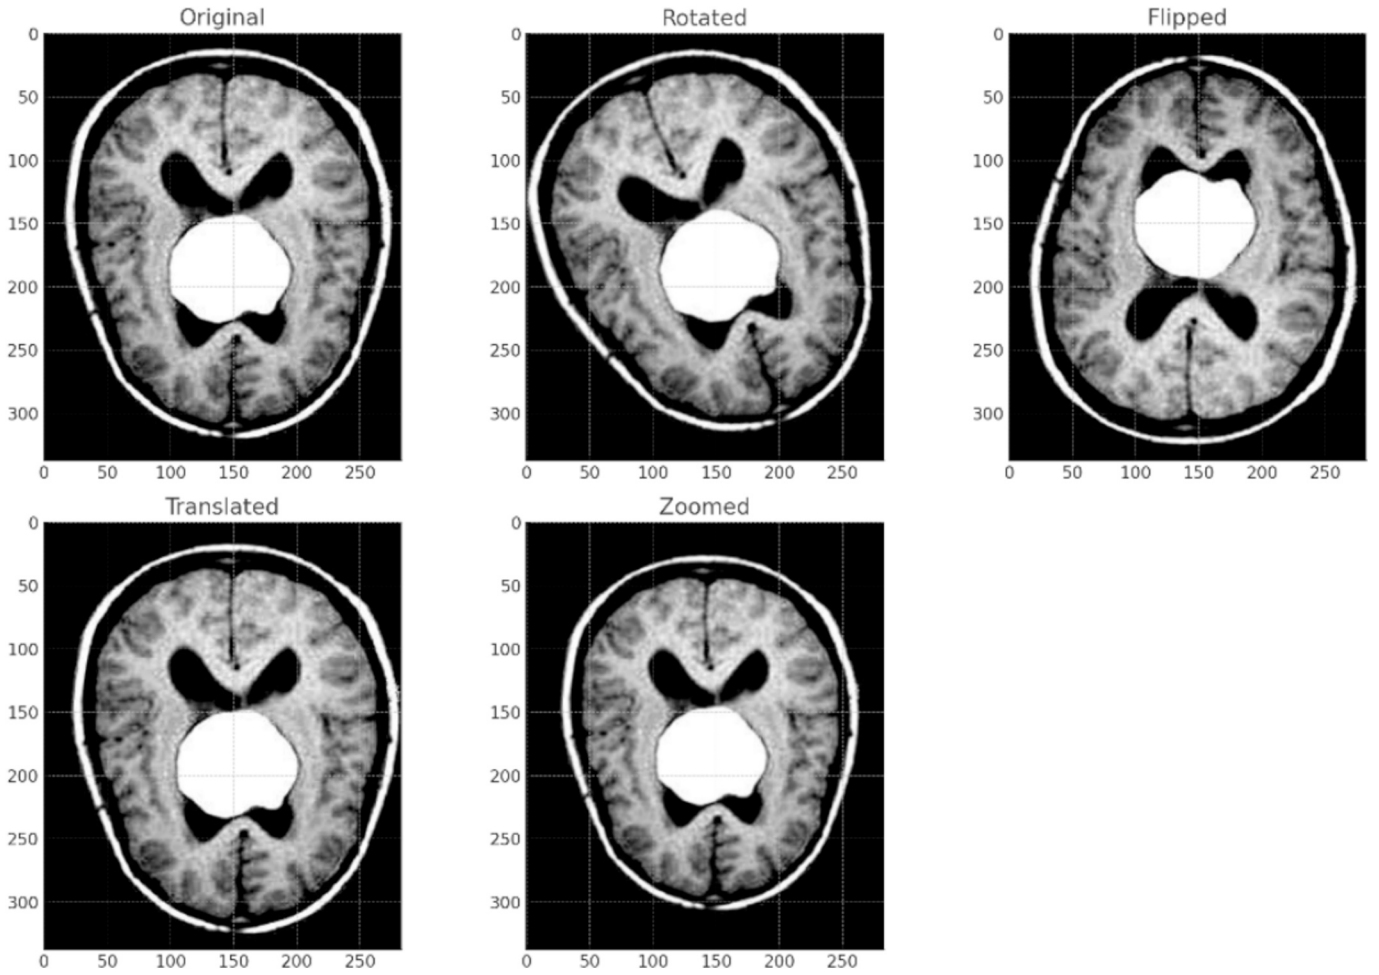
Brain MRI Augmentations.
